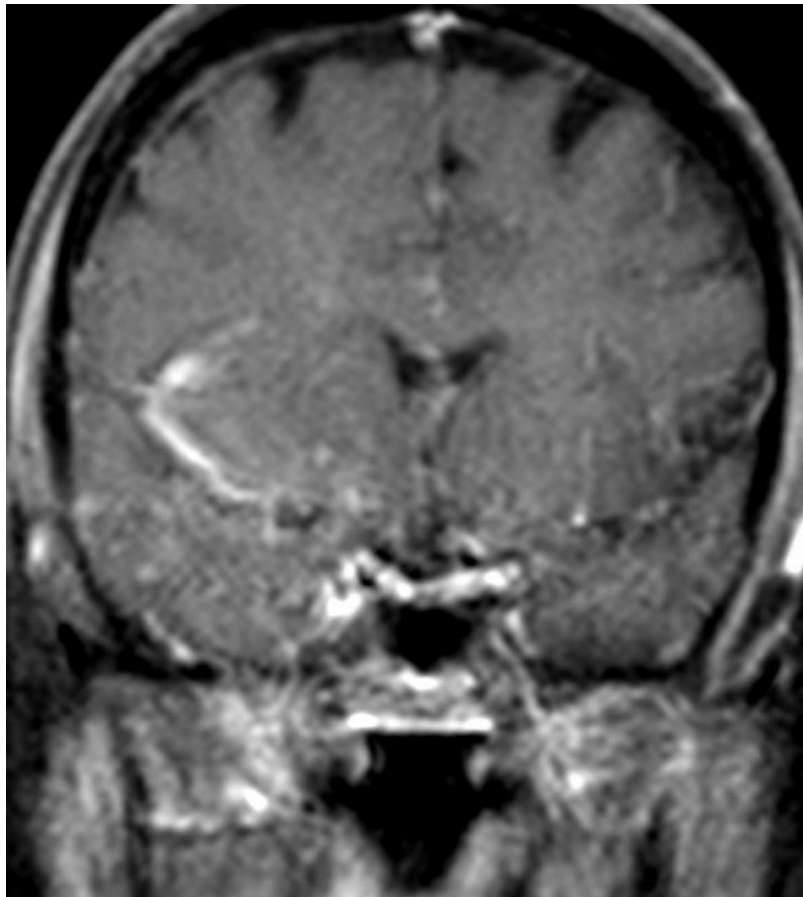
Contrast-enhanced T1-weighted coronal MR image shows a portion of the infected parenchyma as gyriform enhancement along the right insular cortex.
